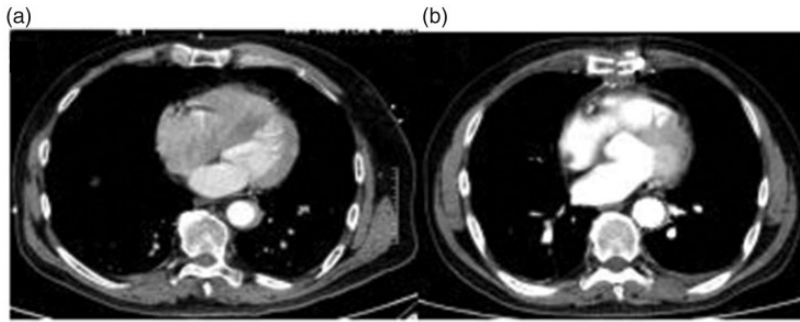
Aortic computed tomography angiography of complex Stanford type B aortic dissection.
